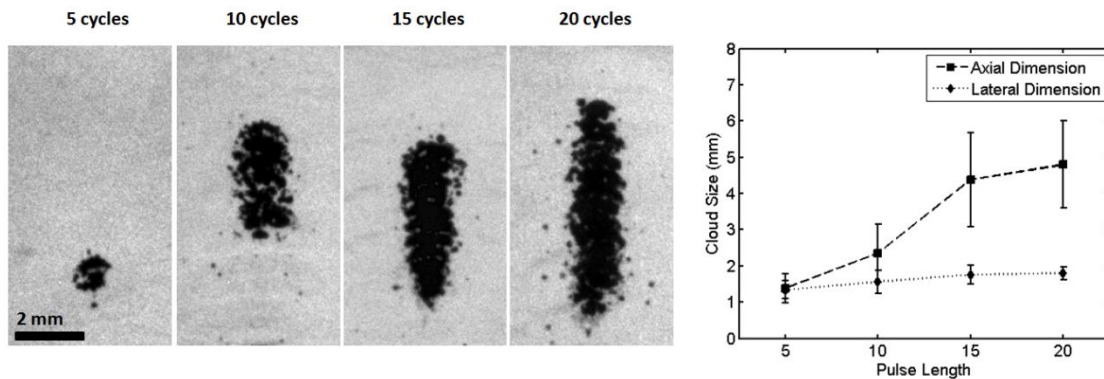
(Top) Typical size and shape of bubble clouds formed during 5, 10, 15, and 20 cycle pulses at 1 MHz. Ultrasound propagation was from top to bottom. All images have been aligned spatially relative to the focus. Note the widths of bubble clouds were similar, but the length increased with cycle number. (Bottom) Cloud dimensions vs. pulse length. The axial length of the cloud increased as the pulse length increased, but lateral size remained about the same.
